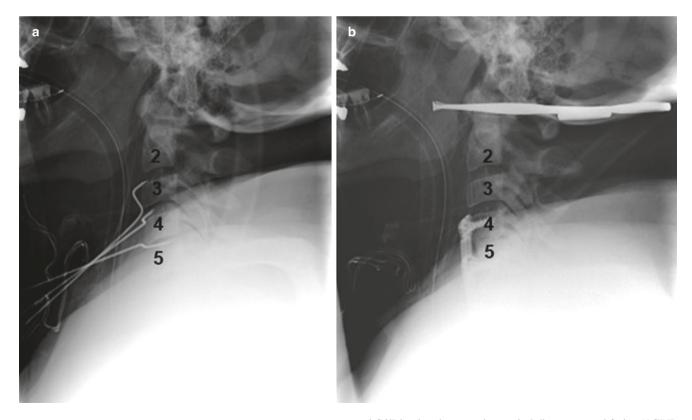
Intraoperative radiographs. A cross-table lateral intraoperative localizing radiograph shows spinal needles in the C2/3, C3/4, and C4/5 interspaces (a). Because of the patient's body habitus, short neck, large shoulders, and submental cyst, it was not possible to visualize the C5/6
